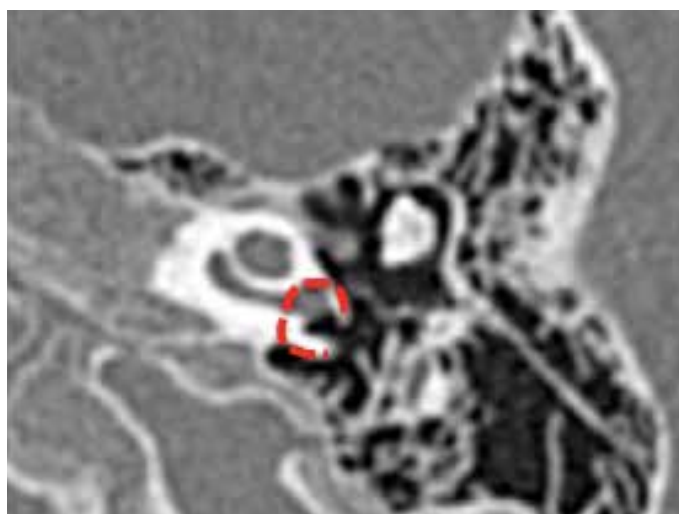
Axial HRCT section showing C-shaped round window niche (RWN). The dashed line represents the edge of RWN.
